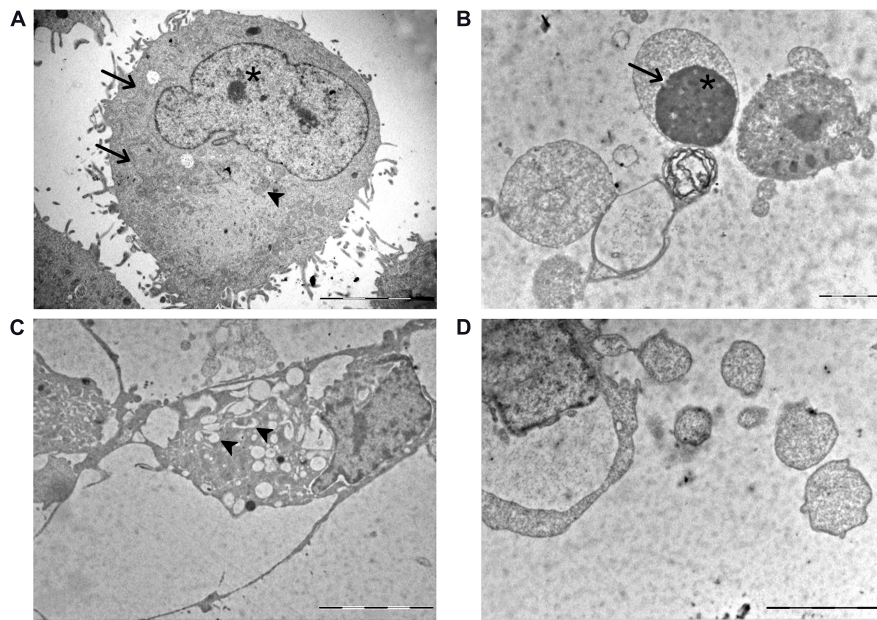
TEM ultrastructural analysis. (A) U251 control cells: *arrowhead* indicates the mitochondria with a physiological feature; *asterisk* identifies a well-visible nucleolus with a decondensed chromatin. A well-organized endoplasmic reticulum (ER) is also visible in the perinuclear zone (*thin arrows*). (B–D) U251 cells after 10 μ M (OC-6-44)-acetatodiamminedichlorido(2-(2-propynyl)octanoato)platinum(IV) [Pt(IV)Ac-POA] 48-h continuous treatment (CT). (B) Chromatin condensation (*asterisk*) and absence of the nuclear envelope (*thin arrows*) in apoptotic cells. (C) Several vacuoles engulfed with cell debris (*arrowheads*) in autophagic cells. (D) Typical necroptotic features accompanied by a partially preserved cytoplasmic membrane. Scale bar, 5 μ m.
